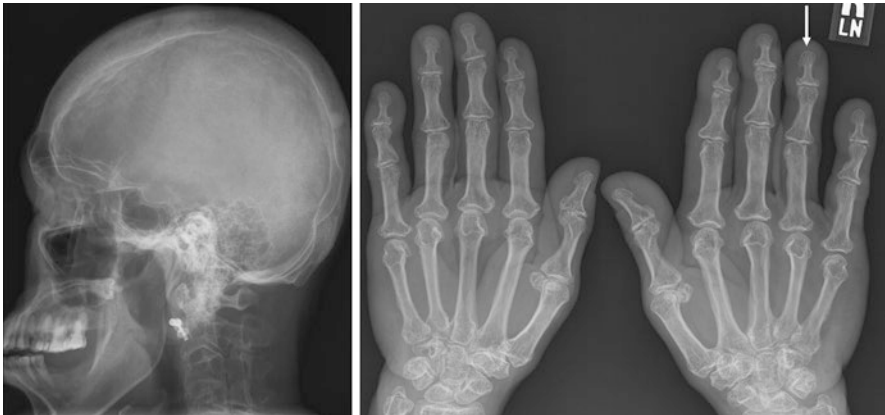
Characteristic radiographic findings of acromegaly. Lateral skull radiograph shows an enlarged and thickened calvarium, frontal bossing, enlarged sella turcica, and enlarged mandible with prognathism. Hand radiograph shows hypertrophy of the phalangeal tufts with the characteristic “spade appearance” (arrow)
